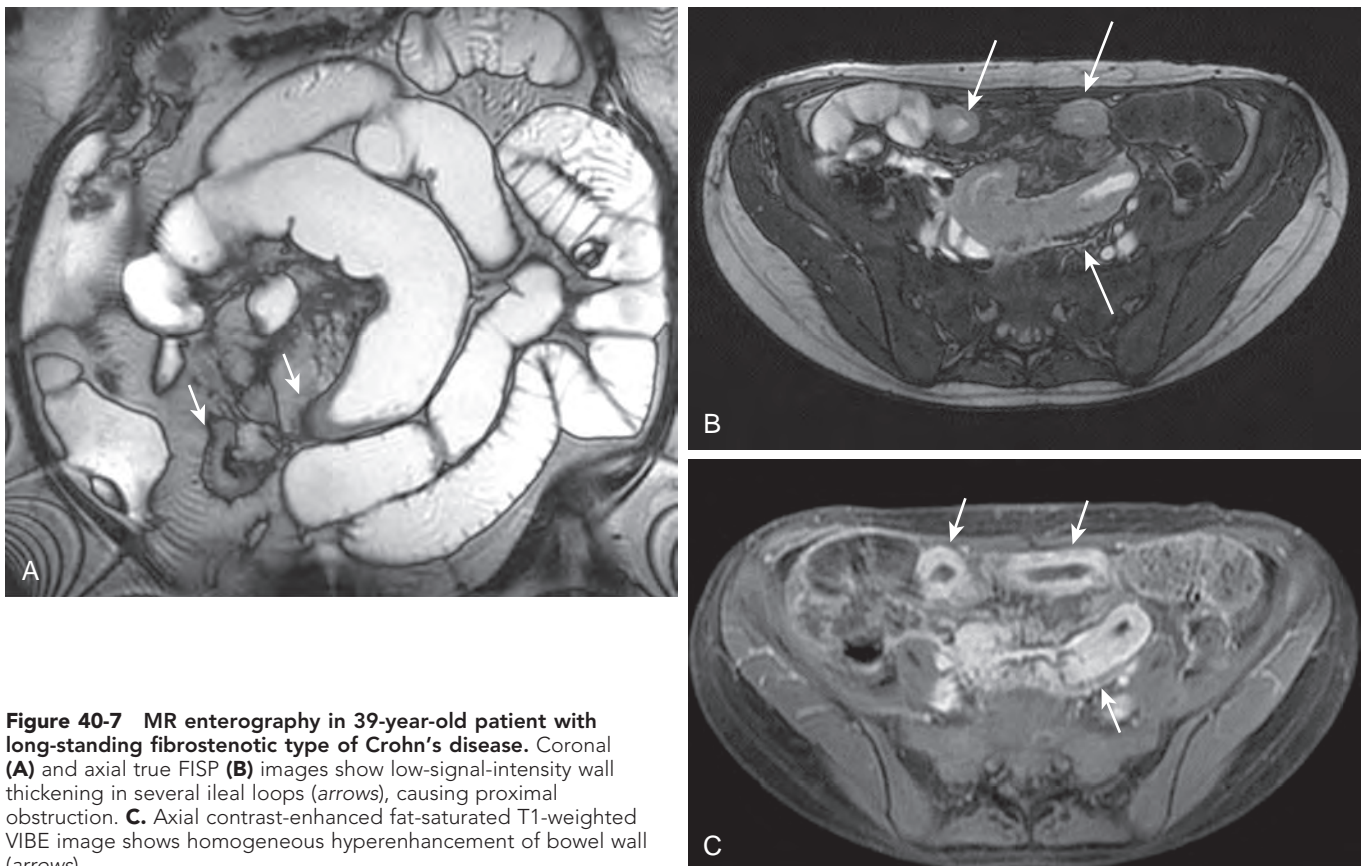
MR enterography in 39-year-old patient with long-standing fibrostenotic type of Crohn's disease. Coronal (A) and axial true FISP (B) images show low-signal-intensity wall thickening in several ileal loops (arrows), causing proximal obstruction. C. Axial contrast-enhanced fat-saturated T1-weighted VIBE image shows homogeneous hyperenhancement of bowel wall (arrows).
